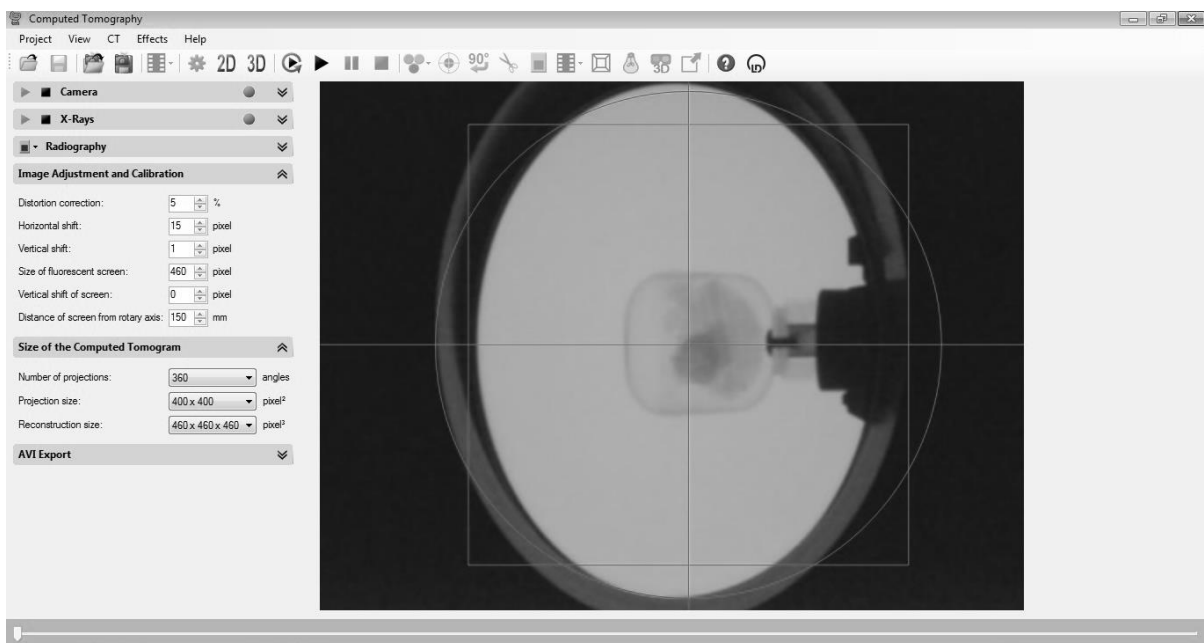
Interface of the “Computed tomography” program
